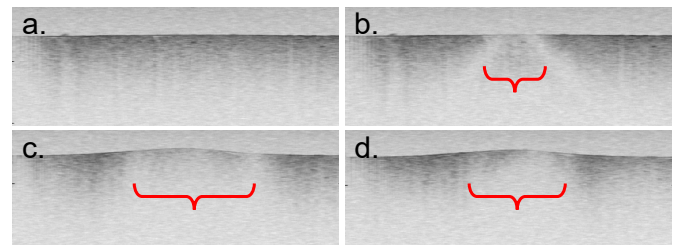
Decomposed images of even depth profiles acquired without ultrasound perturbation (a and c) and of odd depth profiles acquired with ultrasound perturbation (b and d) for ultrasound durations of 50 μs (a and b) and 100 μs (c and d) with a line exposure time of 100 μs . Regions with visible fringe washout are highlighted with the red brackets, and shows an example where residual ultrasound effects can still be detected in depth profiles meant to have no fringe washout.
